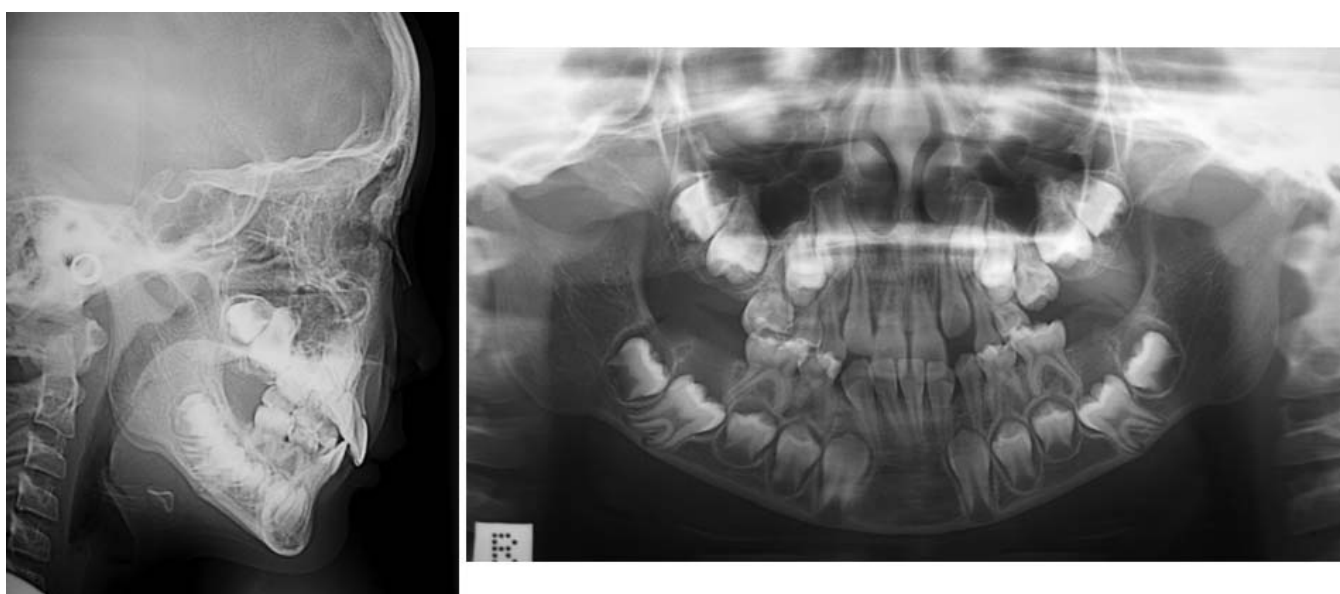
Lateral cephalometric and panoramic radiographs before treatment (age 9 years 2 months).
